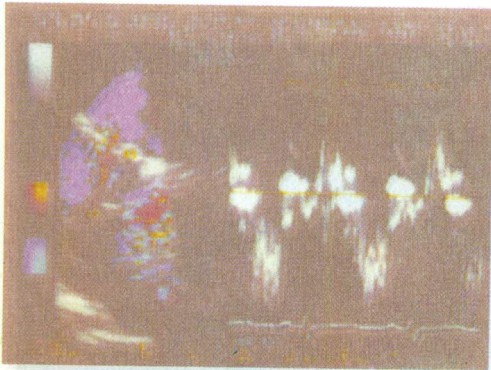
(a): Color Doppler TEE in a child with TOF
